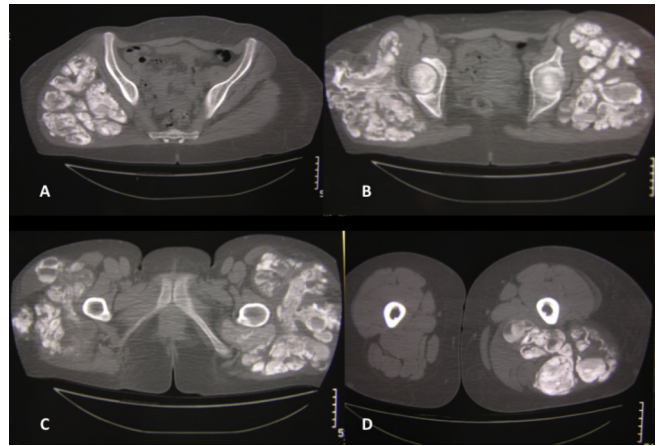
Axial images of CT scan, showing evidence of heterotopic soft tissue calcification, without any involvement of the surrounding skeleton (part figures A, B, C and D show the extension of the heterotopic calcification).
